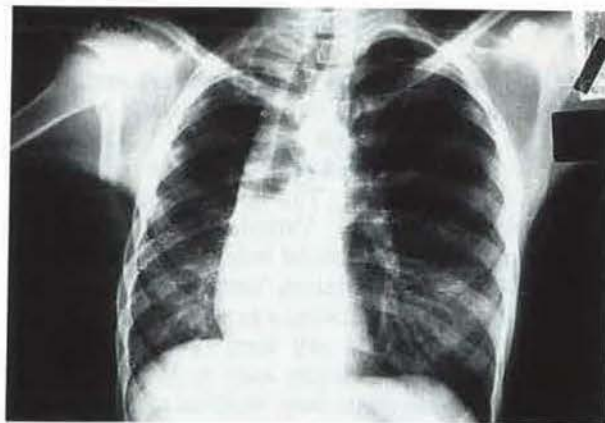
Chest X-ray film showing a loss of volume of the right lung, ipsilateral displacement and anterior herniation and hyperlucency of the left lung.
